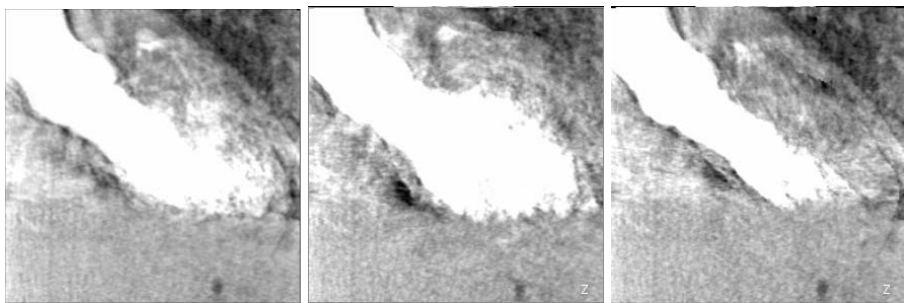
Reconstructed CT volumes using the estimated 3D motion for the patient dataset. Left: Ungated reconstruction. Middle and Right: Motion-compensated reconstruction for the end-diastolic and end-systolic phases, respectively.
